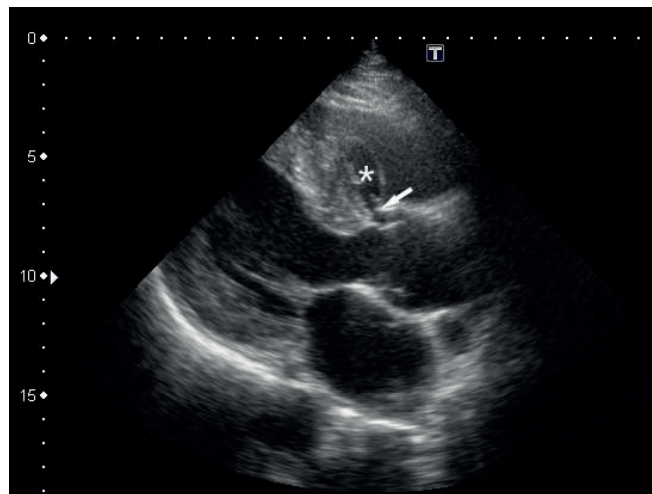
Echocardiography. Parasternal long-axis view. Echo-lucent cavity close to the right side of the interventricular septum
